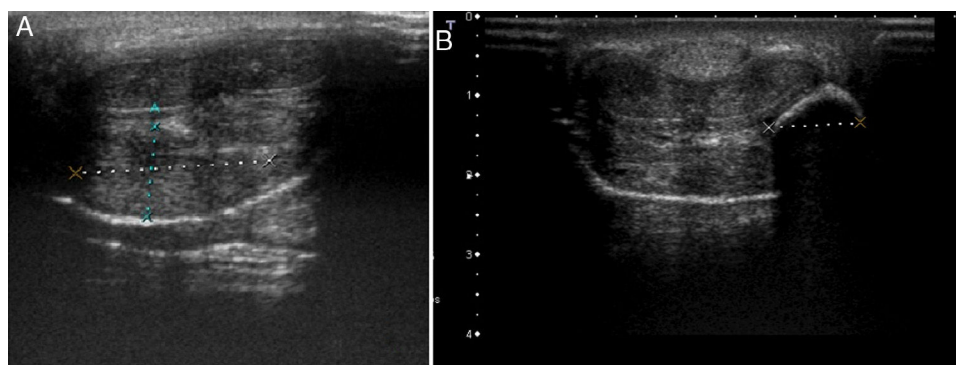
High-resolution ultrasound with linear 14MHz probe. A, Marked focal thickening of subcutaneous tissue of the right ventrolateral aspect of the penis, measuring approximately 5×2.5 cm. Preserved corpora cavernosa. B, Oval pseudocystic lesion with marked posterior acoustic shadow.
